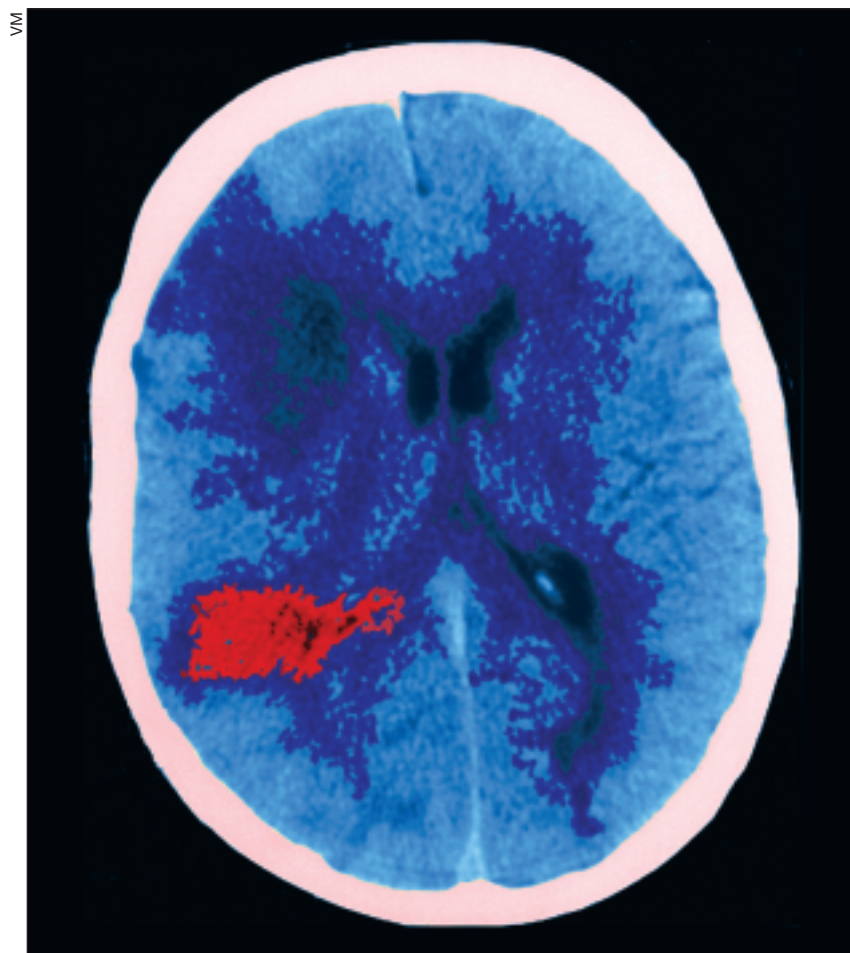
A CT scan of the brain can support the diagnosis of epilepsy in older people, often demonstrating, as here (false colour), evidence of cerebrovascular disease
